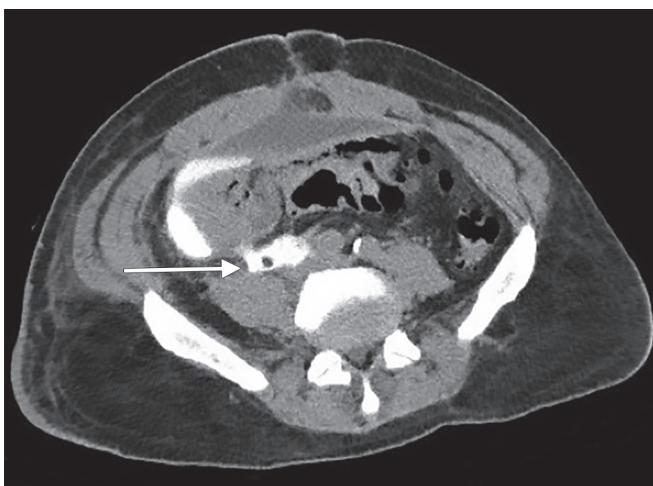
Axial view of CT IVP on POD 18 after wound drainage showed Creatinine of 22.2 mg/dL. The arrow shows the ureter lumen (in black) with the white contrast extravasation around it
